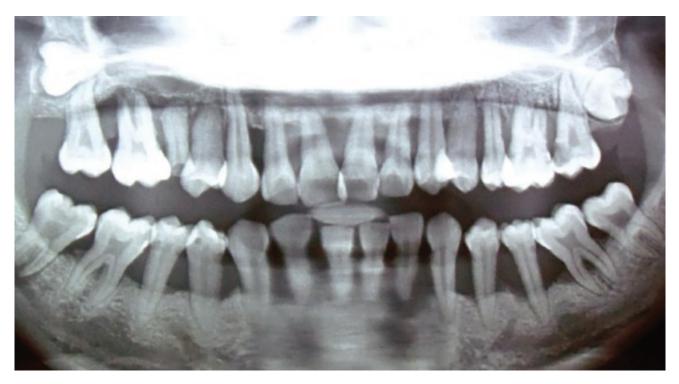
Patient's panoramic radiograph September 25, 2013.
